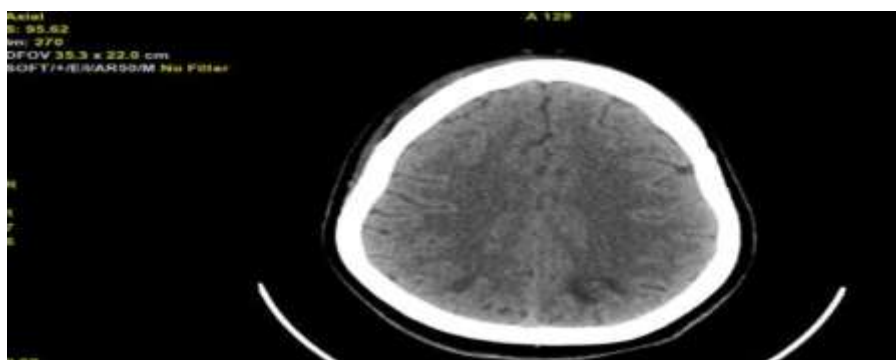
Non-contrast axial CT image of the brain shows ill-defined subcortical hypodensity in the bilateral high parietal lobes, suggestive of posterior reversible encephalopathy syndrome in the appropriate clinical setting.
